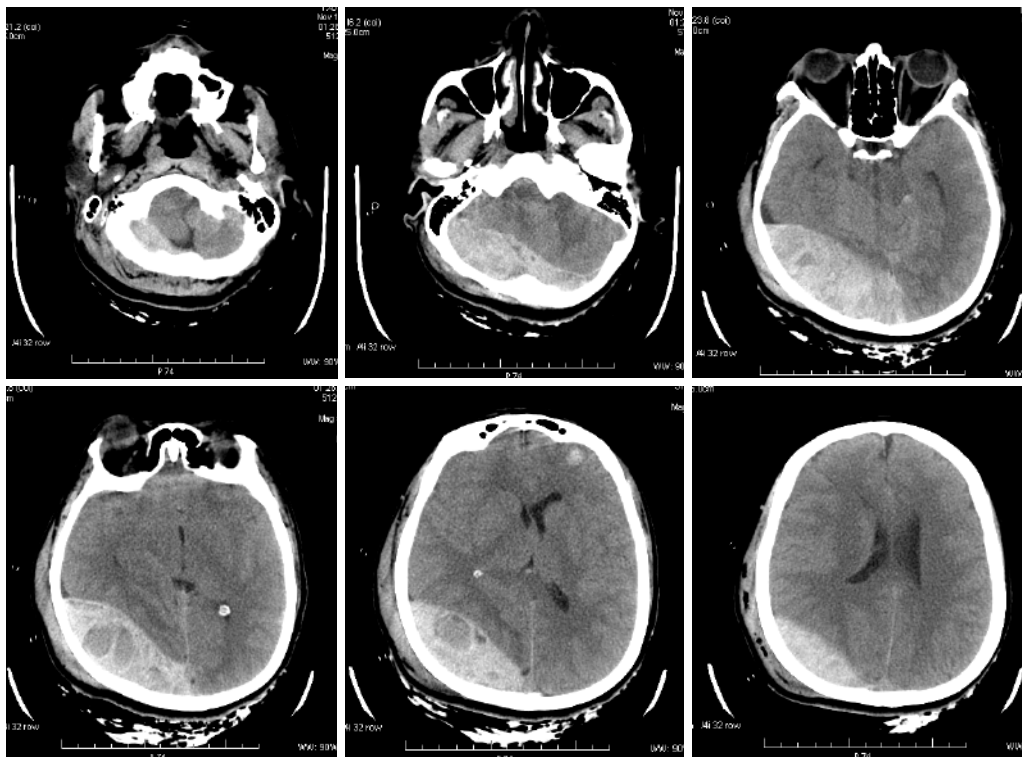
Emergency head CT showed an epidural hematoma in the right posterior fossa, with a volume of about 170ml. The hematoma stretched across the transverse sinus and sigmoid sinus, with obvious brain stem compression. The lowest level of the hematoma was at the level of the foramen magnum, and the highest level was at the level of the lateral ventricle.
